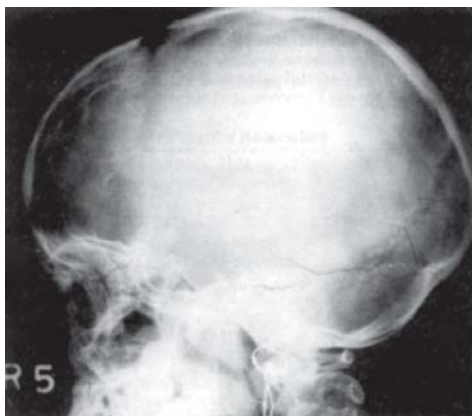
X-ray skull showing sutural diastasis in ICSOL (posterior fossa tumor). The boy was hospitalized for severe intractable headache (occipital).
